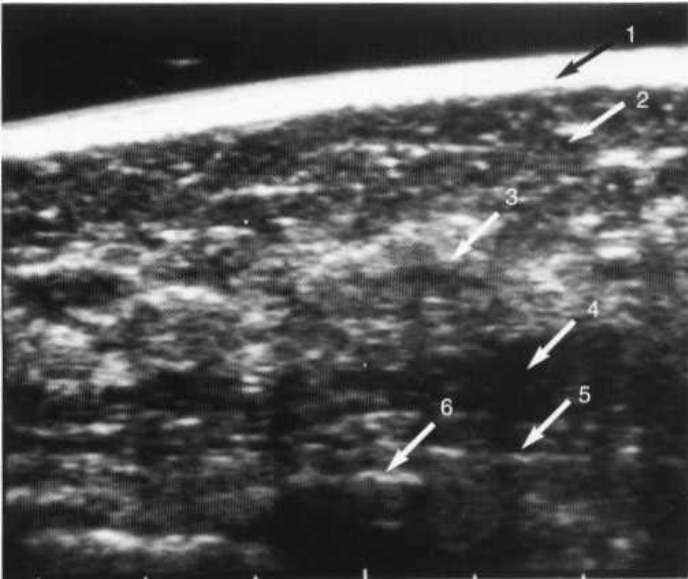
Normal breast ultrasound: 1 = skin; 2 = subcutaneous fat; 3 = glandular tissue; 4 = retromammary fat; 5 = pectoralis muscle; 6 = rib.
